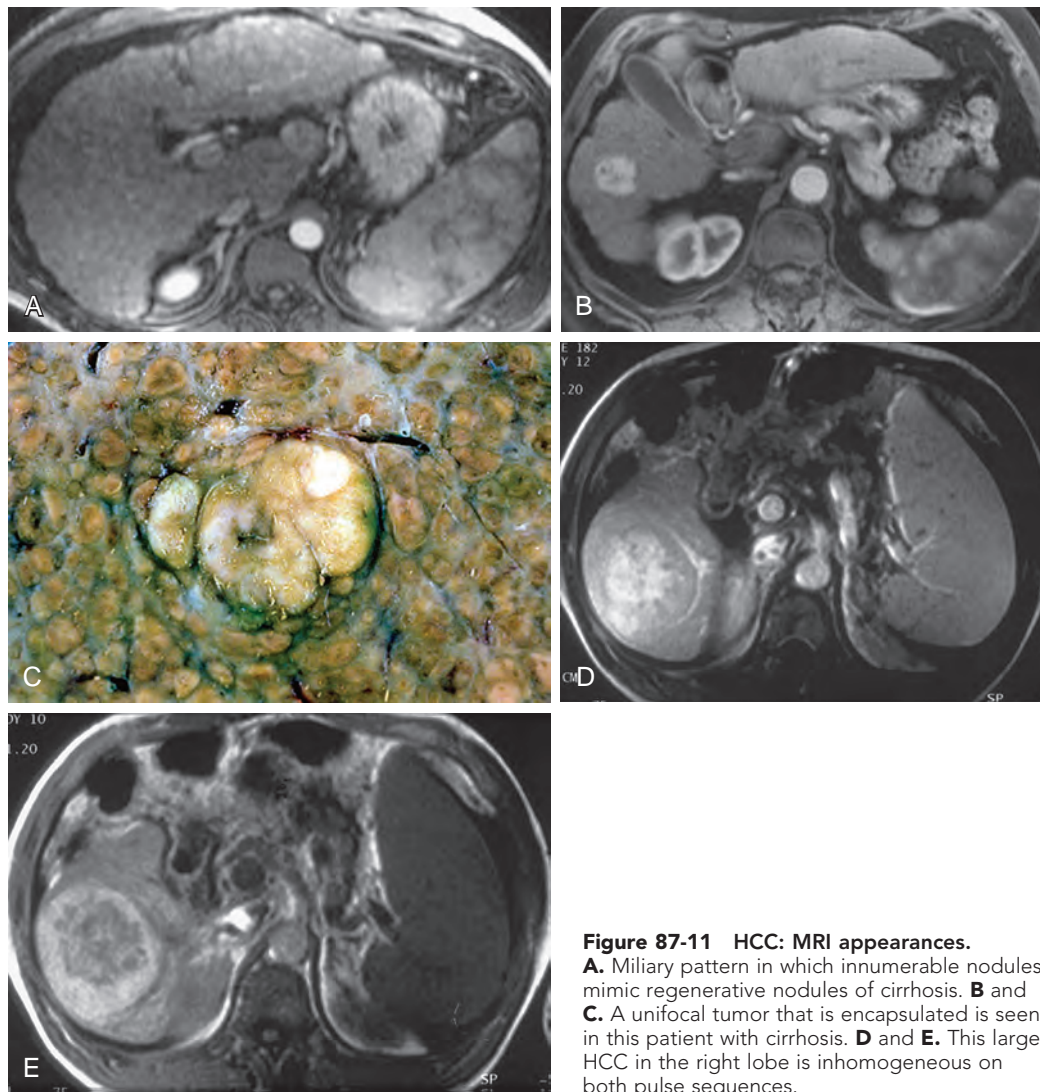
HCC: MRI appearances.
